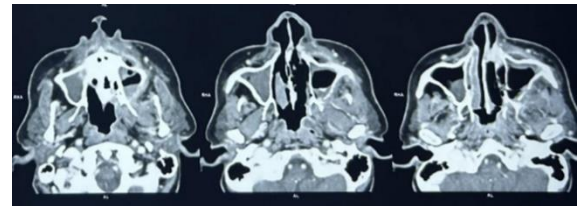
CT image showing thickening of the bilateral nasal cavity walls and nasal septum
